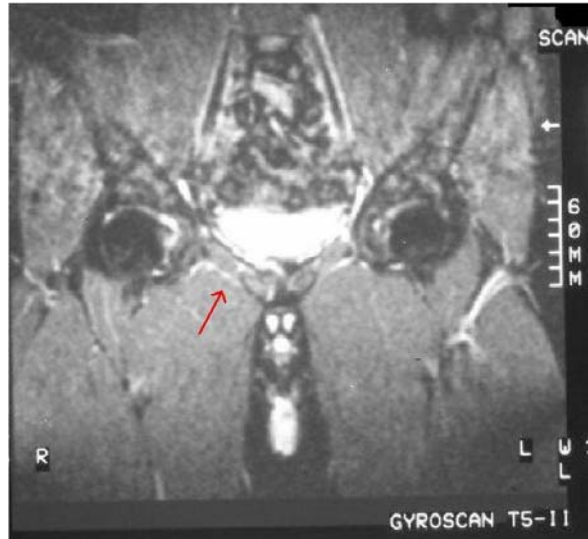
MRI image obtained by STIR sequences. Reduction in hyper intensity and intraspongious oedema previously pointed out (Red arrow).
